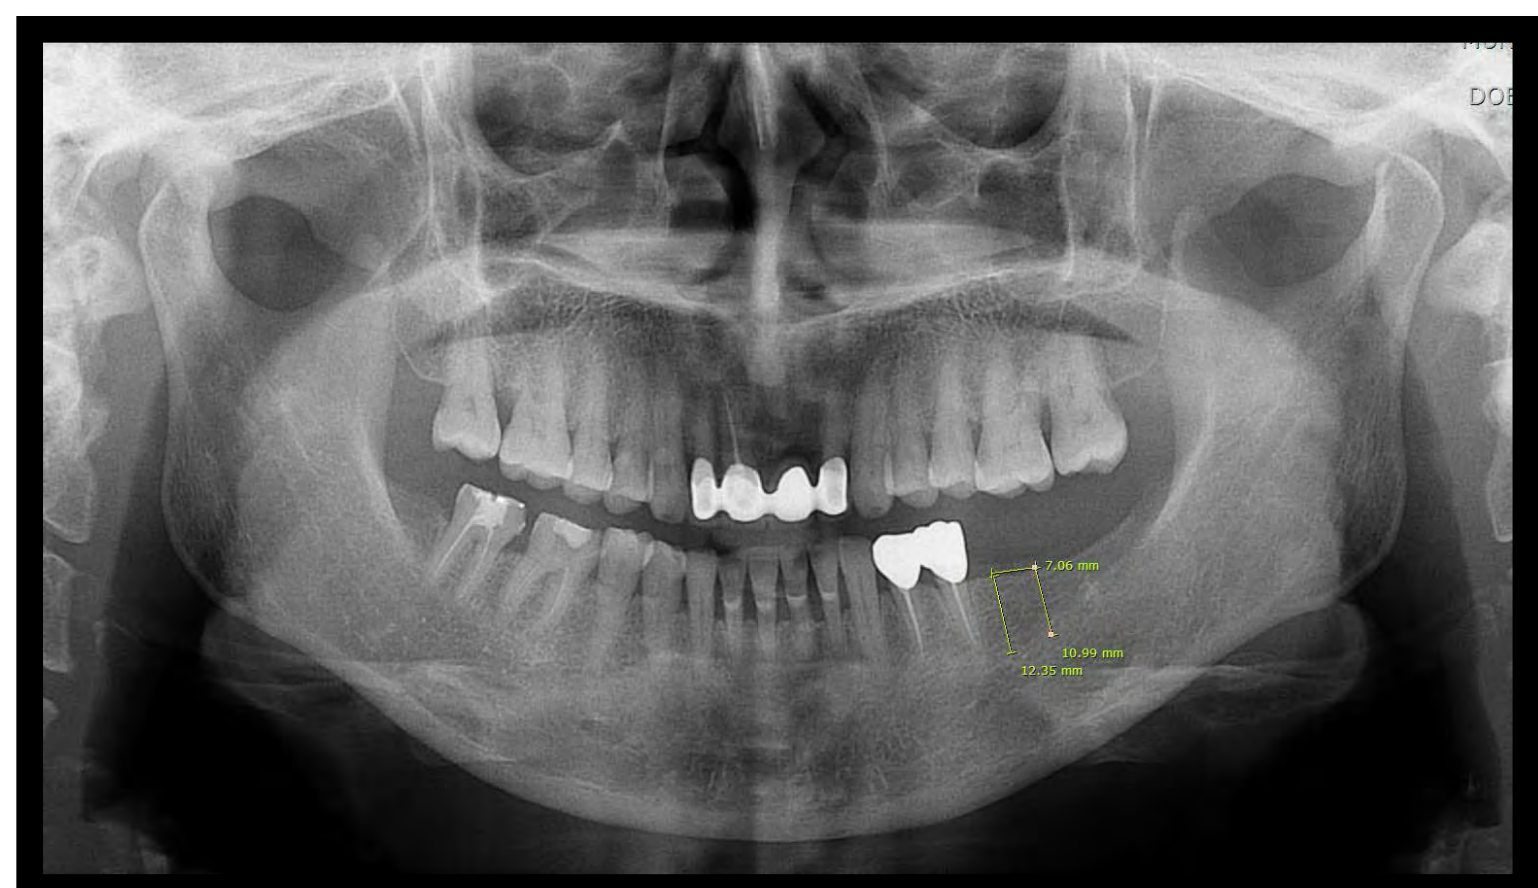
Direct digital (CCD) panoramic radiograph
